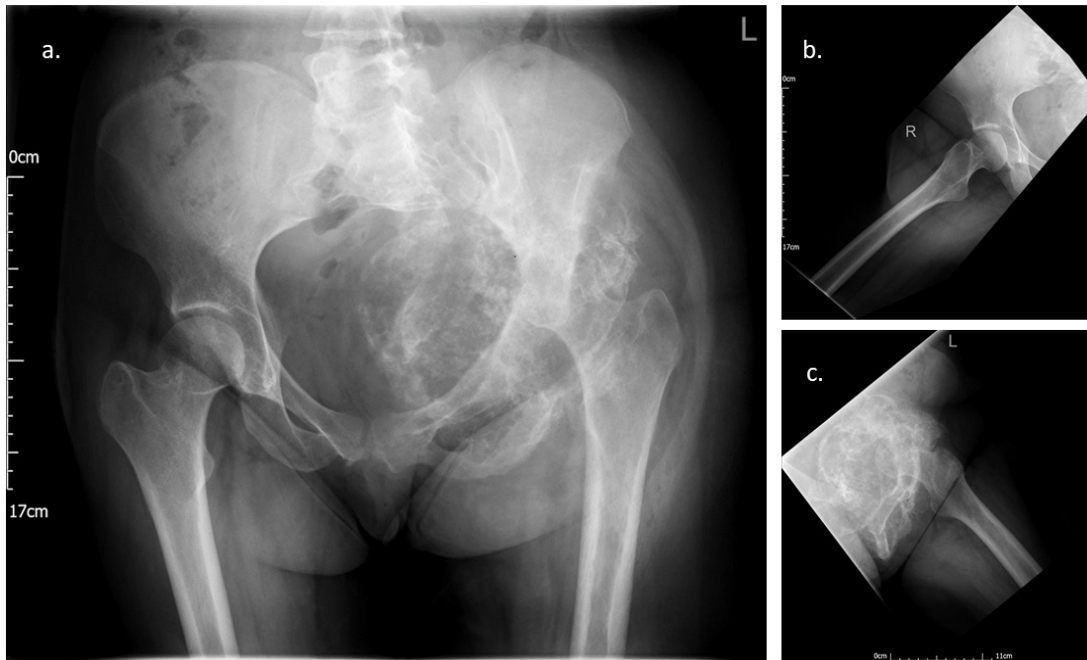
Telangiectatic osteosarcoma in a 24-year-old woman. Anteroposterior X-ray of the pelvis shows a large aggressive tumour of the left hemipelvis (anterior a., lateral right b., and lateral left c.).
